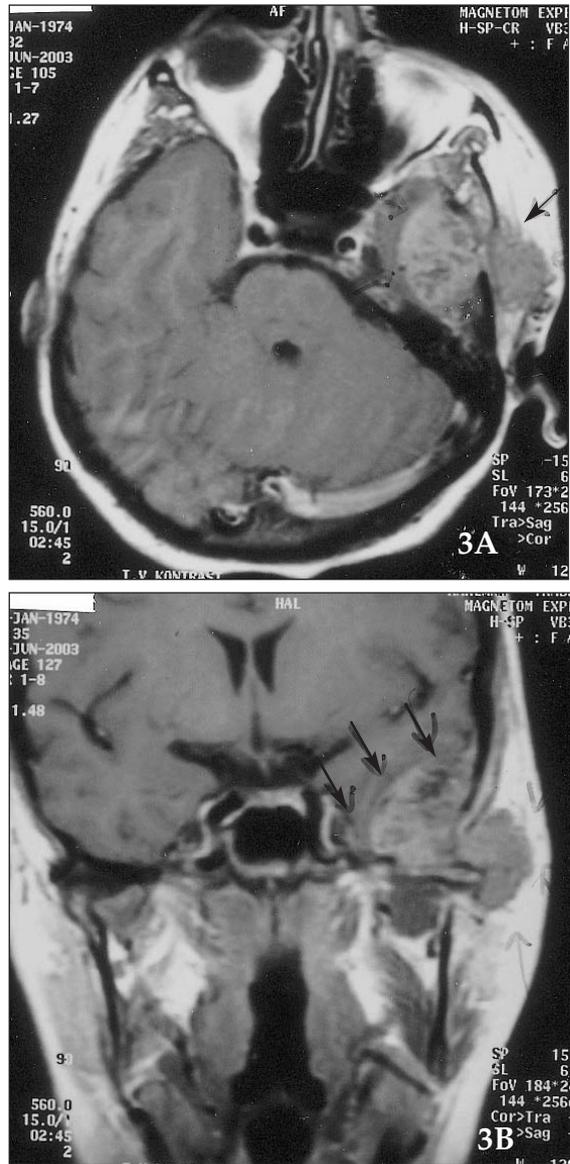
After contrast administration, there was heterogeneous enhancement within the tumor on axial T1-weighted (A) and coronal T1-weighted (B) MRI images.
